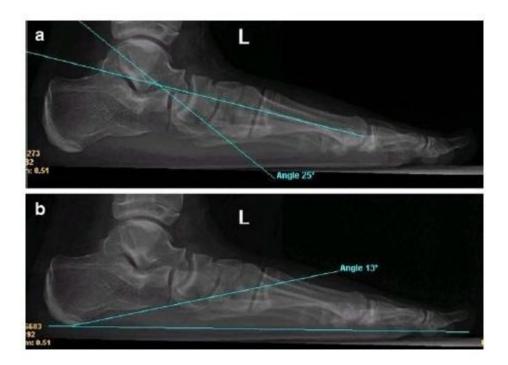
Radiographic parameters, a) Talus-first MT angle, b) Calcaneal inclination angle (93).
